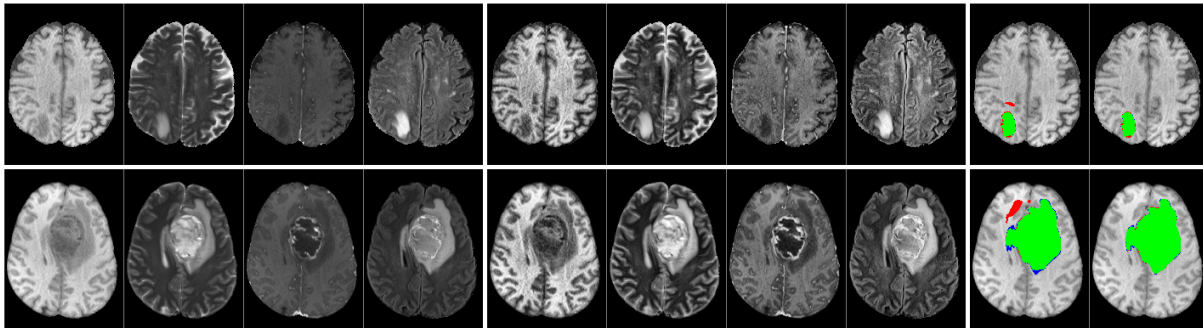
Segmentation outcome demonstrated on two selected slices: the first four images in each row present the input data (channels T1, T2, T1c and FLAIR), the next four images show the preprocessed data after CLAHE, while the last two images exhibit the segmented tumor after the first and the second U-Net stage. Color codes: green - TP, blue - FP, red - FN.
